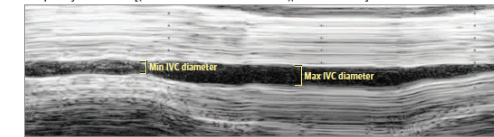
Inferior Vena Cava (IVC) Ultrasonography
